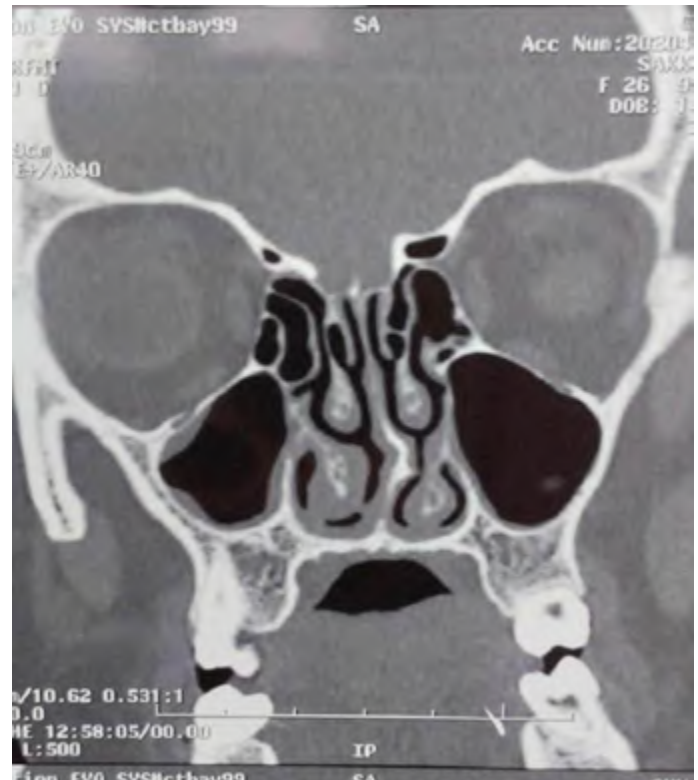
Maxillofacial computed tomography showed a deviated nasal septum with a left concha bullosa with middle and inferior turbinate swelling and hypertrophy.
